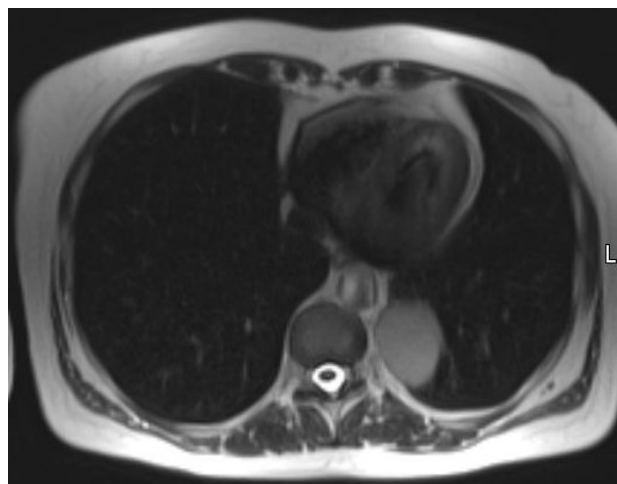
29-year patient's HASTE axial MRI view shows signal hyperintensity in the oval left paravertebral lesion (arrow).
